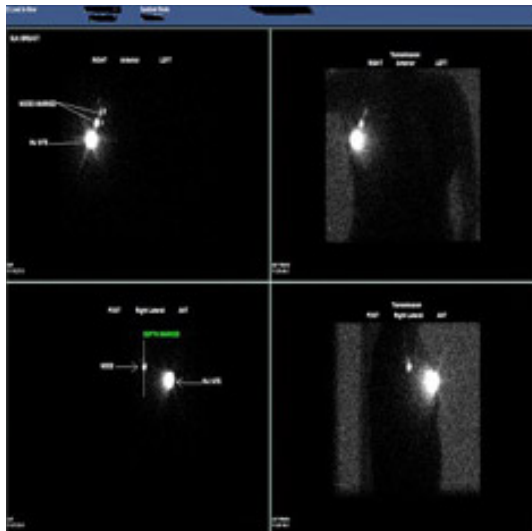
Traditional lymphoscintigram after peri-areolar injection of Tc-99m. Note the ambiguity of number of nodes as seen in the different projections from the same patient.
